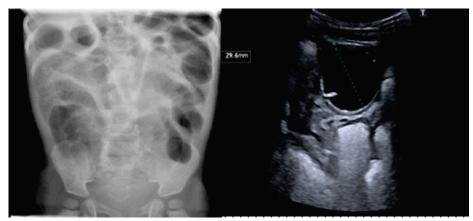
(a)Supine X-ray abdomen and (b)ultrasound scan appearance which raised suspicion of duplication cyst.
